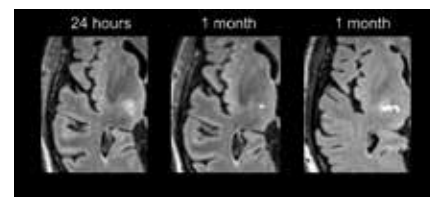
Typical response patterns in one patient to MRgFUS thalamotomy targeting the Ventral intermediate nucleus of the thalamus (Vim) for Essential Tremor. Representative Fluid Attenuation Recovery sequences (FLAIR) at 24 hours (left) with perilesional oedema. This patient experienced transient ipsilateral facial paraesthesia which resolved in parallel with the imaging findings of a discrete thalamotomy lesion at 1 month (middle). For comparison, the post-operative imaging of a different patient who developed permanent gait disturbance and dysgeusia. Imaging at 1 month post-thalamotomy demonstrates a "lateral-tail" [11] recognised as an unpredictable consequence of MRgFUS in 7% of cases.
